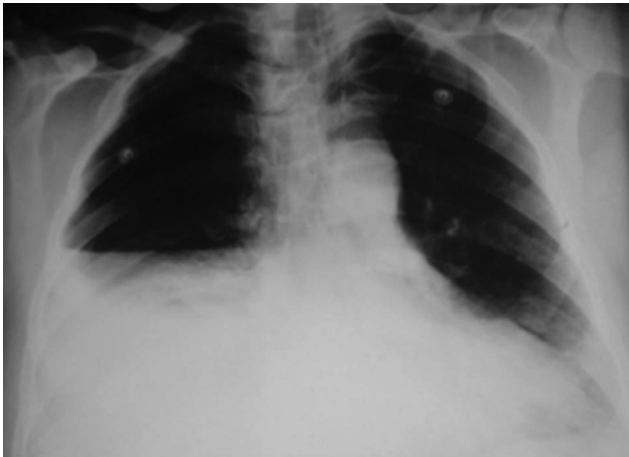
Chest X-ray demonstrated right hydropneumothorax in spontaneous perforation of distal esophagus (Boerhaave's syndrome).
